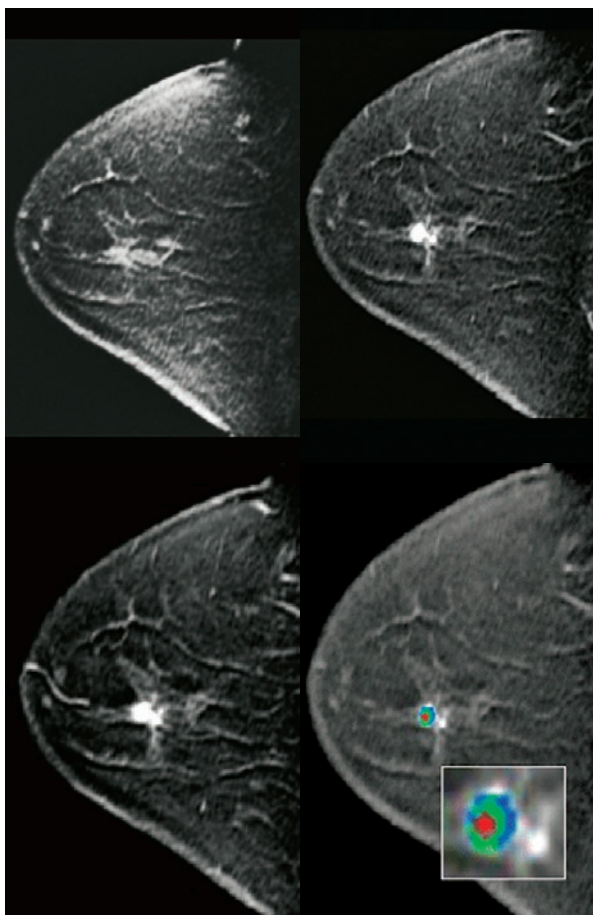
Representation of lesions on breast MRI images using CAD systems in the study of Lehman et al.
